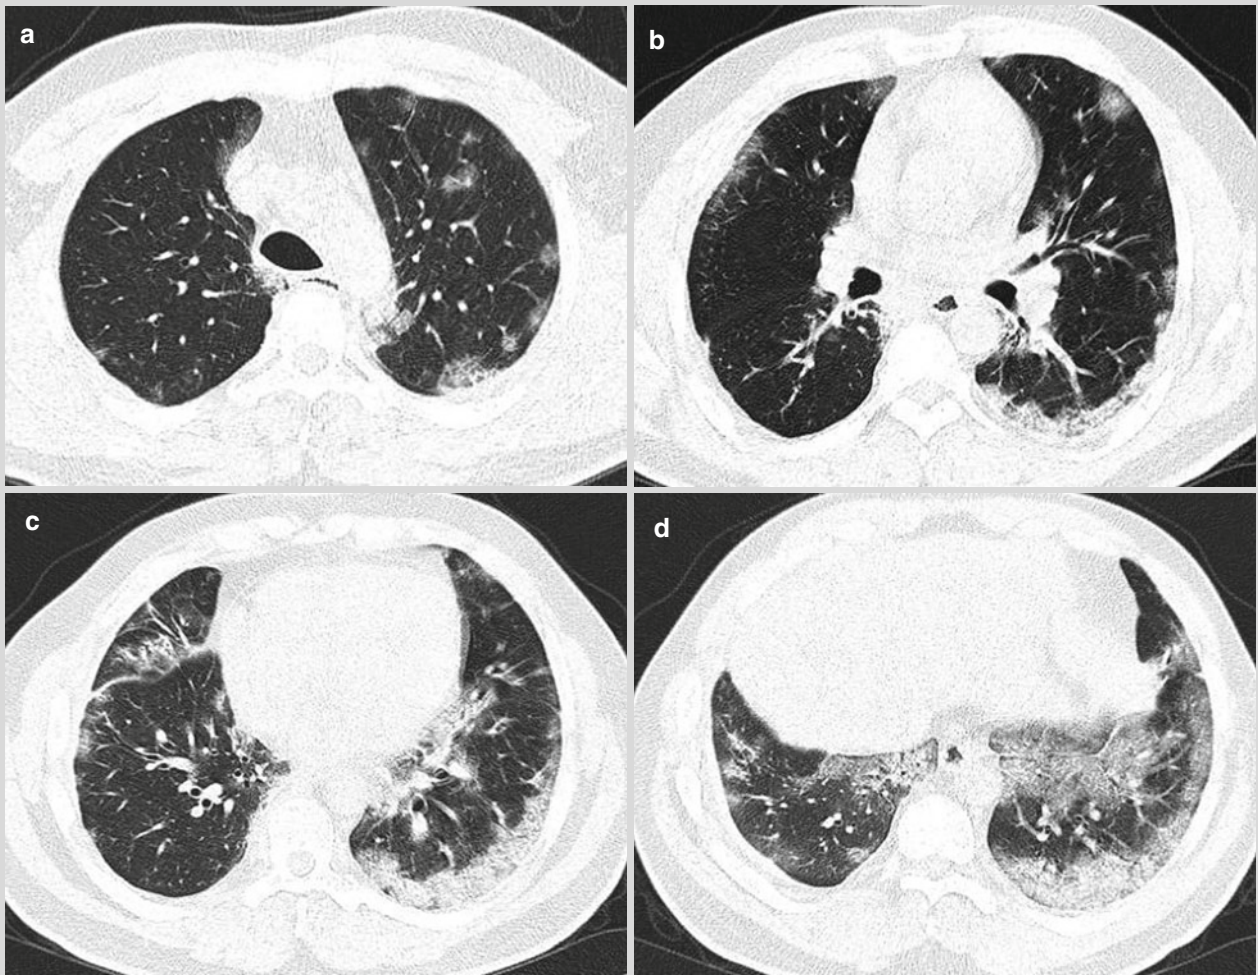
Chest CT scan showed multiple flakes and cords like high density opacity and ground glass opacity in both lungs that was predominantly in the left lower lung lobe. The lesions were revealed to be commonly located at the lung margin (a–d)
